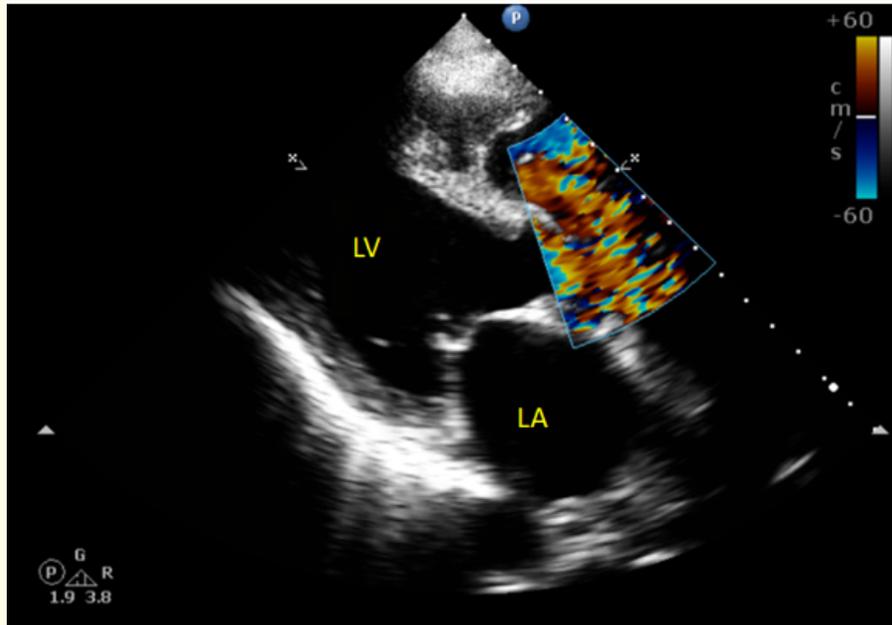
2D transthoracic echocardiogram modified parasternal long axis view, colour doppler showing ruptured sinus of valsalva aneurysm arising from right coronary sinus draining into right ventricle with continuous flow in systole and diastole. LA: Left Atrium; LV: Left Ventricle.
